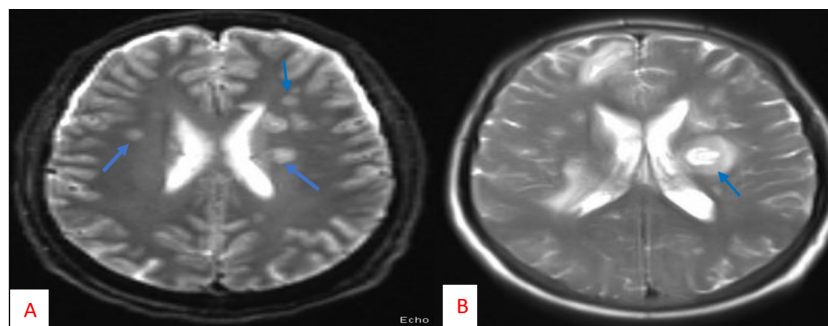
3 (A)First T1Wi MRI head showing bilateral cerebral abscess(B) Repeat MRI of head T1Wi after 20days of first MRI showing new lesions
